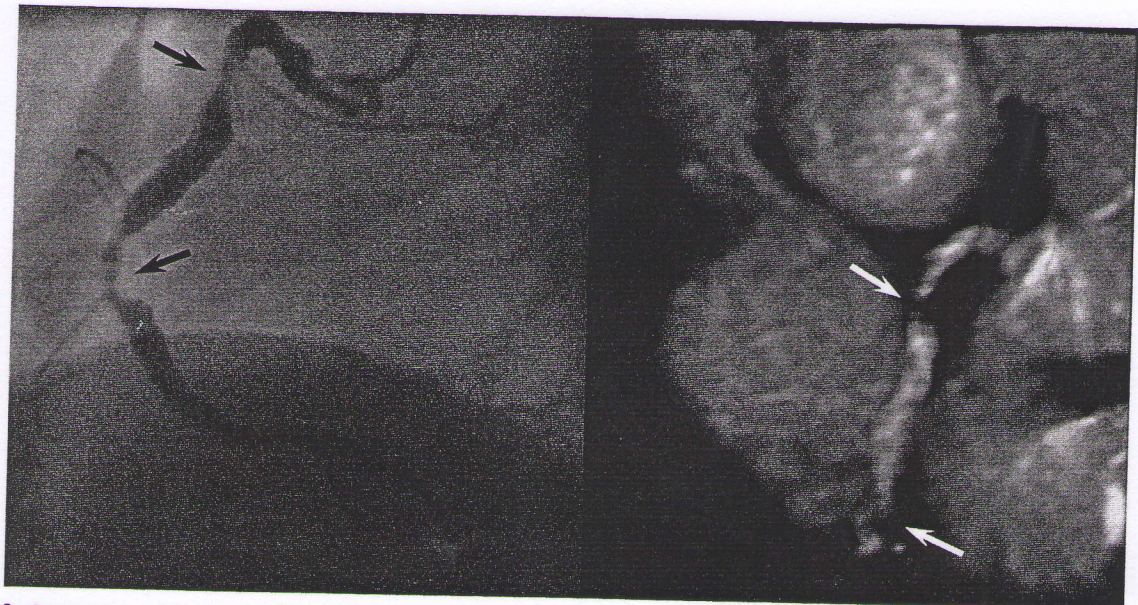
Comparison of x-ray invasive coronary angiography (*left*) in a patient with two tight stenoses of the right coronary artery (*black arrows*) with coronary CMR performed during a breath-hold showing similar appearances (*white arrows*). (From van Geuns RJ, Wielopolski PA, de Bruin HG, Rensing BJ, Hulshoff M, van Ooijen PM, et al. MR coronary angiography with breath-hold targeted volumes: preliminary clinical results. *Radiology* 2000; 217[1]:270. Reproduced with permission.)
